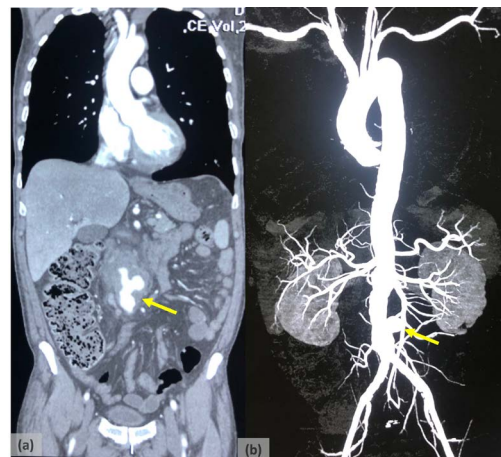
Computed tomography images of the PAEF in coronal section. (a): the infrarenal aortic aneurysm with effacement of fat planes with duodenum and soft tissue thickening (marked with yellow arrow); (b): reconstructed aortogram images showing the saccular infrarenal aortic aneurysm (marked in yellow arrow).
